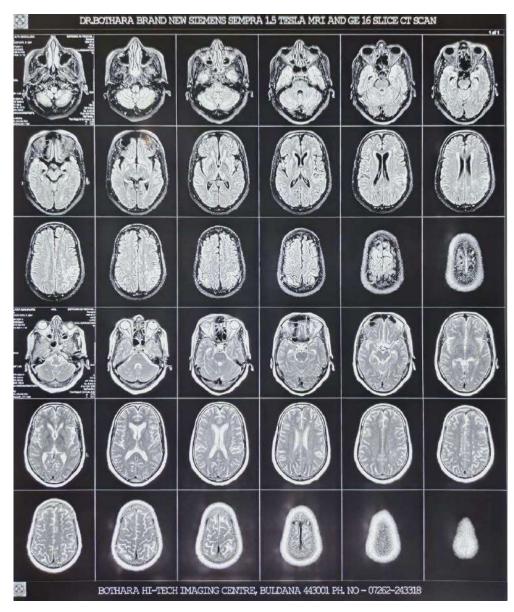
T1 weighted MRI with flair axial with lower T2.
